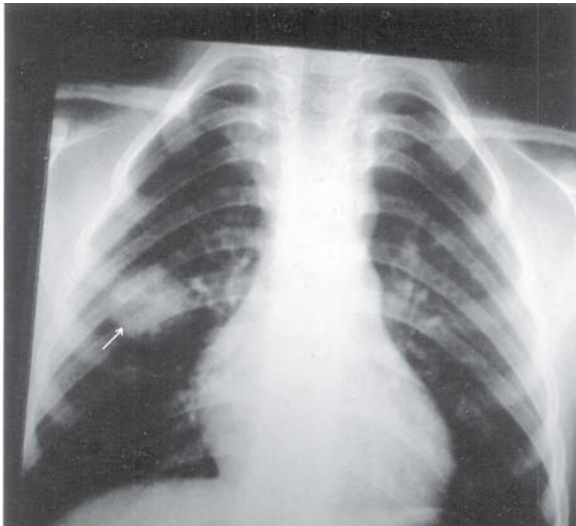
Posteroanterior chest radiograph shows a round mass (arrow) in the right middle zone.
